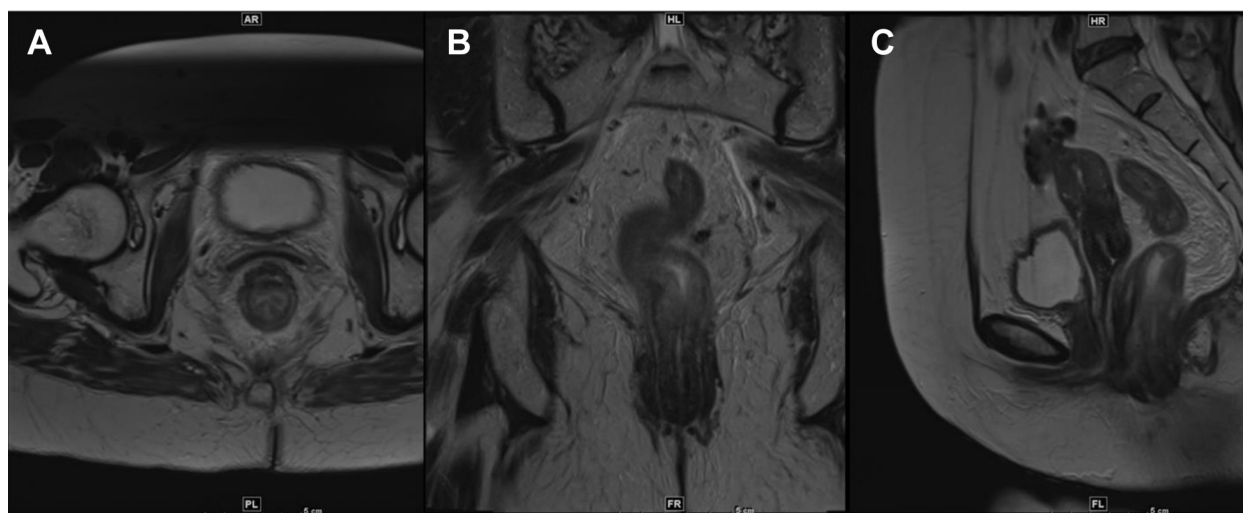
Five months post-radiation therapy (RT) magnetic resonance imaging (MRI) with contrast (A = axial, B = coronal, C = sagittal).
